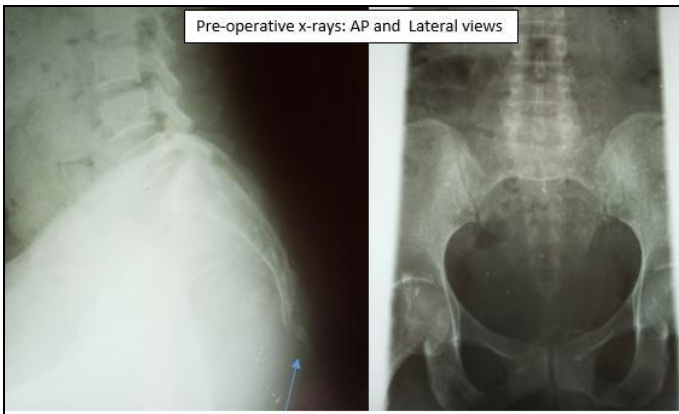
Pre-operative x-rays with arrow pointing to the fractured coccyx
